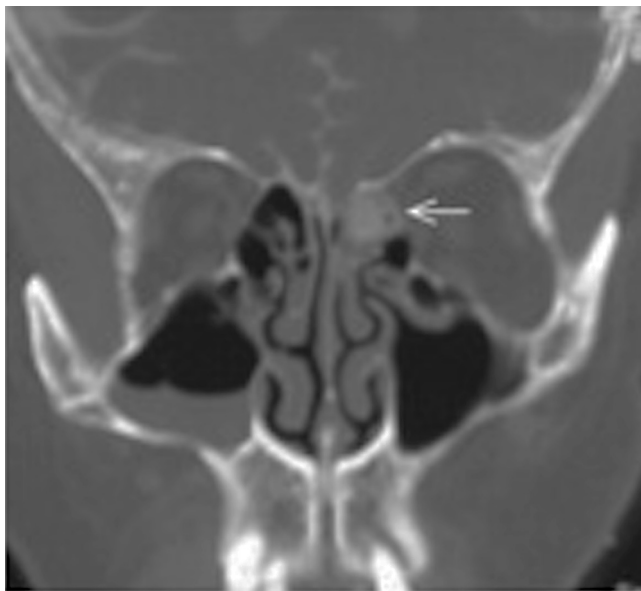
Direct coronal computed tomography (CT) cisternography image of a 25-year-old woman with postoperative rhinorrhea, demonstrating leakage into the ethmoid sinus (arrow). Because a Valsalva maneuver was contraindicated in this patient with accompanying meningoceles, images were obtained after keeping the patient in the Trendelenburg position for 30 minutes. Note the lower attenuation of the contrast-enhanced subarachnoid spaces on the left when compared with the right side, due to washout and leaking of the contrast material and cerebrospinal fluid.
